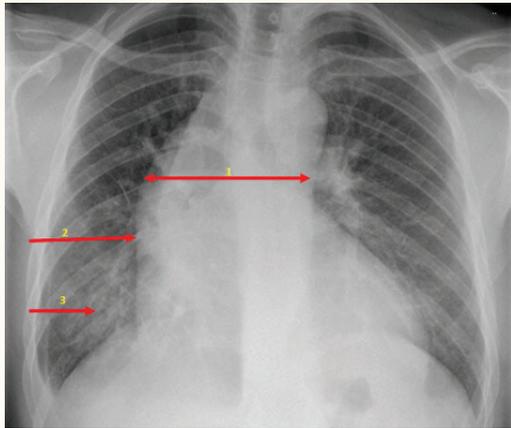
Frontal chest X-ray showing mediastinal widening (top arrow) and dilatation of the ascending aorta (middle arrow) with signs of heart failure (bottom arrow).
